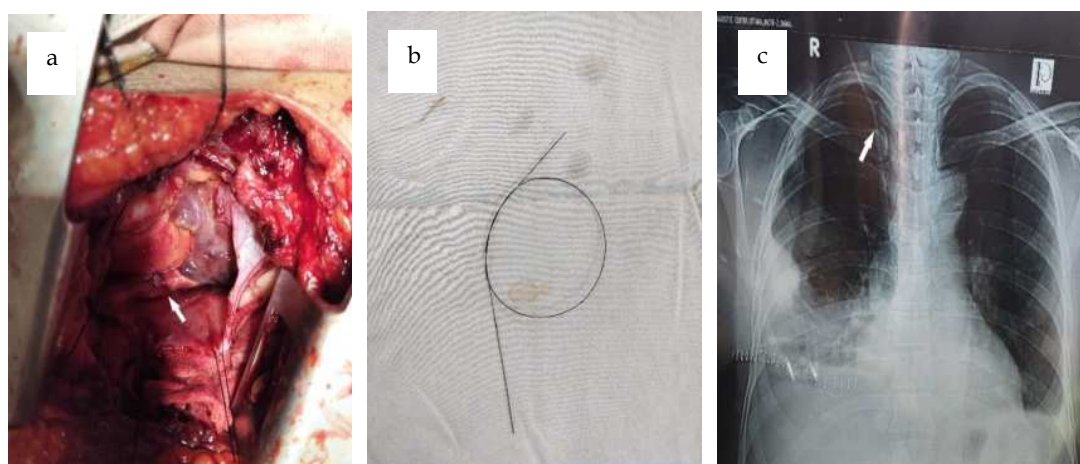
Operative and postoperative images: a) closed stoma over superior vena cava, b) removed guidewire, and c) postoperative X-ray after removal of the guidewire central venous catheter in situ.
